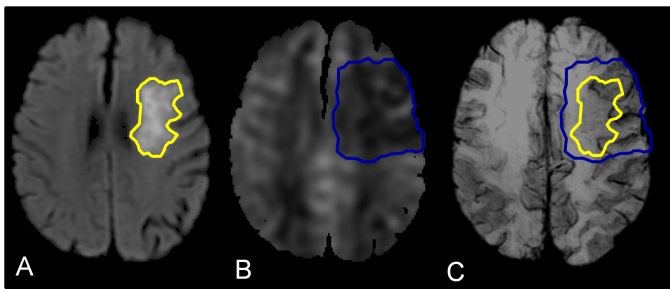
After registration of the DWI, ASL, and SWI images to MNI space, the ROIs of restricted diffusion (A, DWI) and perfusion defect (B, ASL) were manually selected and applied to the SWI image (C) for calculation of the area percentages of IBS.
